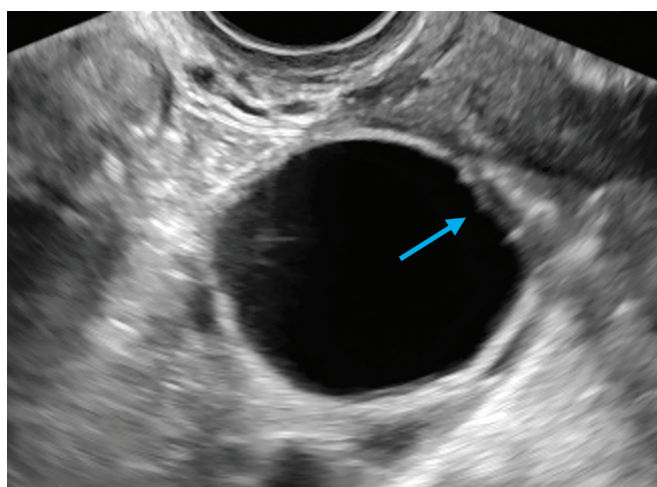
B-mode ultrasound image of a follicle of which rupture is impending showing mild separation of inner wall (blue arrow) at 2 o'clock and 6 o'clock positions.
